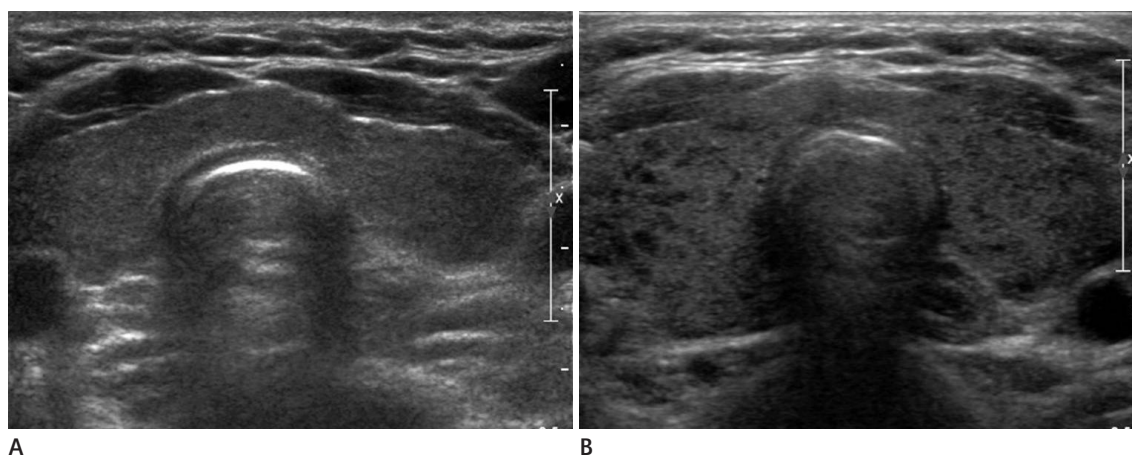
Ultrasound (US) of group Ho and group He.
